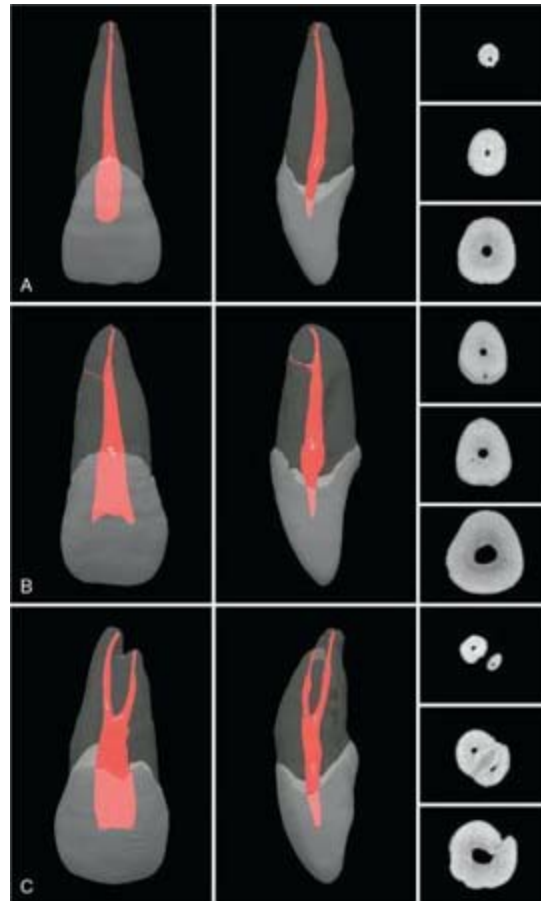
μ CT scans of maxillary central incisors. A, Common anatomic presentation. B, Central incisor with a lateral canal, which is common. C, Rare multiple-canal variation. All teeth are shown from both a buccal (vestibular) and a proximal perspective, along with the cross-sectional anatomy at the coronal, middle, and apical levels. (See Video 7.3 online at the Expert Consult site for rotational views of these teeth.)
